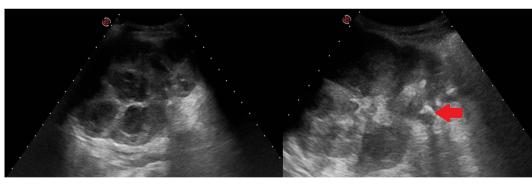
B-mode ultrasound images demonstrating an enlarged right kidney with multiple hypoechoic nodules and renal calculi demonstrating posterior acoustic shadowing (arrow).
